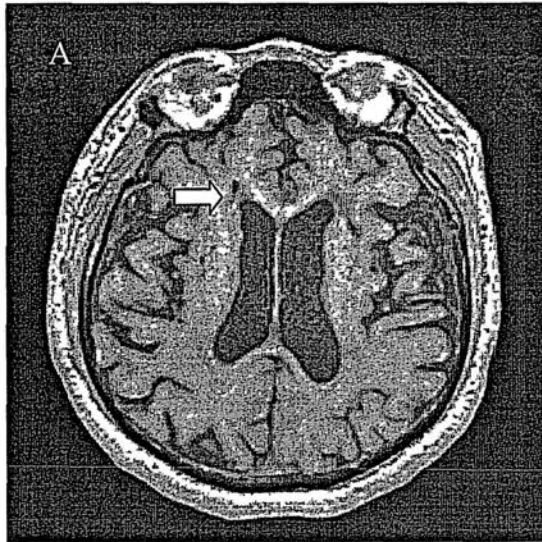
Lacunar infarct and microbleed on MRI. A: Right frontal lacunar infarct on T1-weighted imaging; B: Left thalamic microbleed on gradient-echo T2*-weighted MRI.
